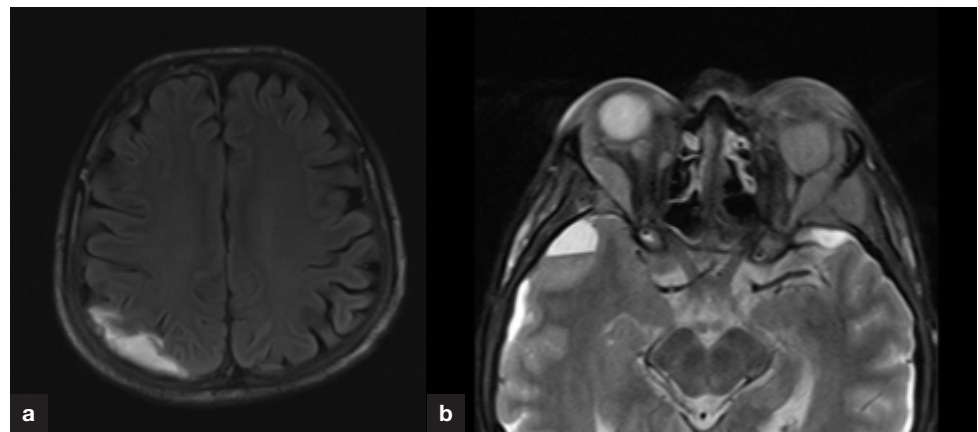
a. Axial fluid-attenuated inversion recovery magnetic resonance imaging of the brain revealed a right parietal dural-based lesion. b. Axial T2-weighted magnetic resonance imaging of the orbits showed bilateral extraconal and left lacrimal gland involvement.
